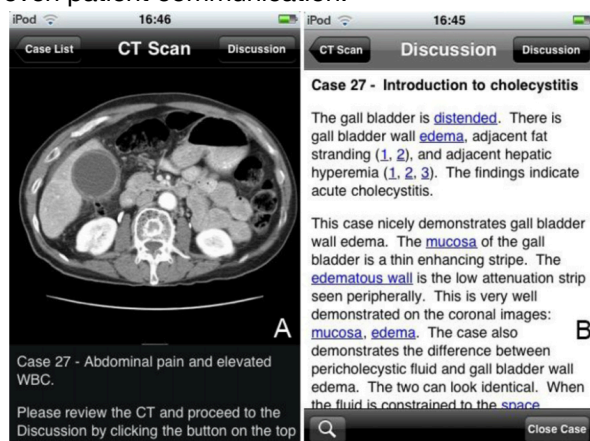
CT-scan on iPad with discussion (20)
